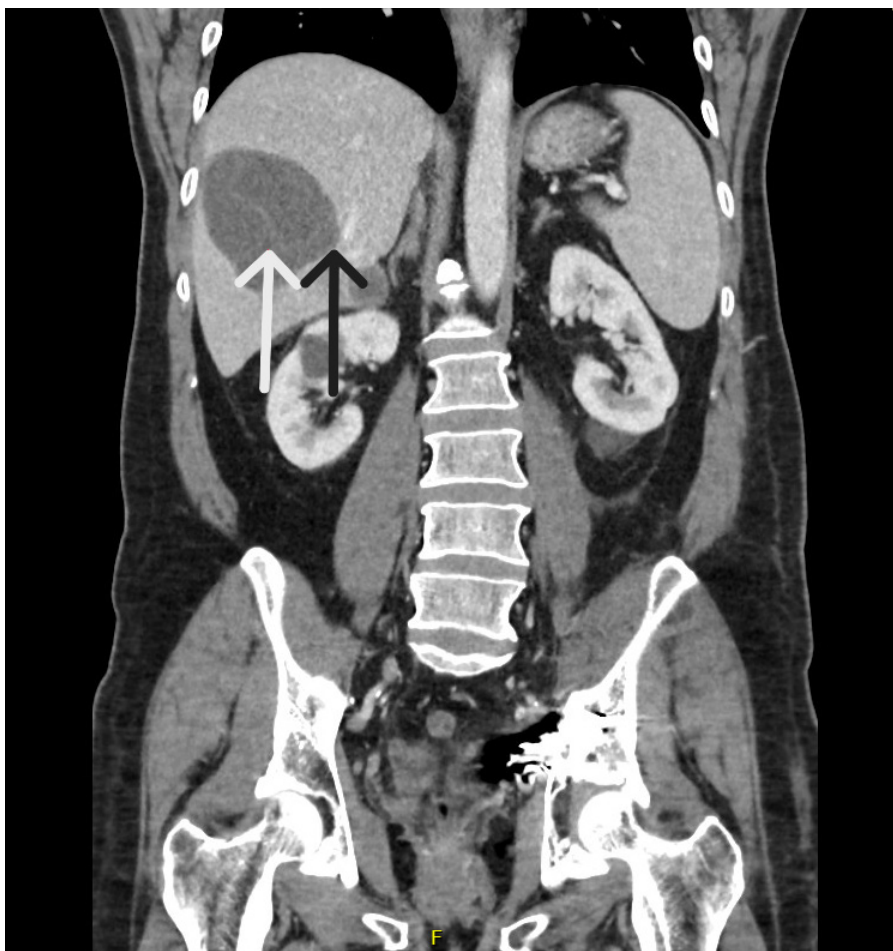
Selected coronal image of contrast-enhanced portal venous phase CT imaging demonstrating non-rim-enhancing hepatic cysts (black arrow) with serpiginous soft tissue filaments within (white arrow).
